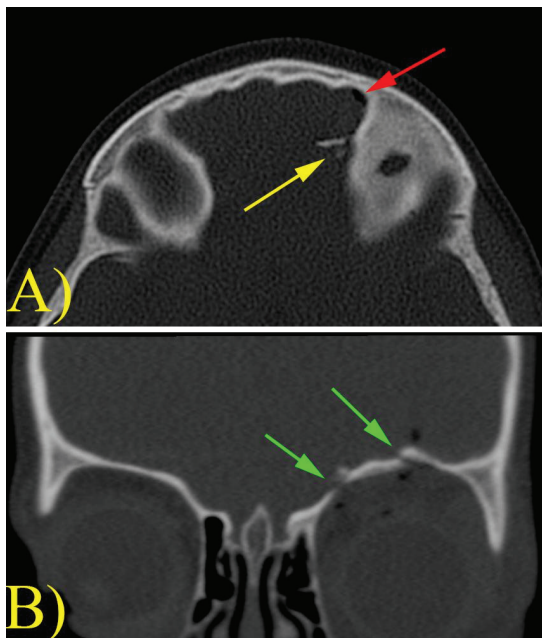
Cranial computed tomography scan. In the axial image (A), the pneumocephalus is marked with a red arrow, and the bone defect is marked with a yellow arrow. In the coronal view (B), the bone defect is marked with green arrows
